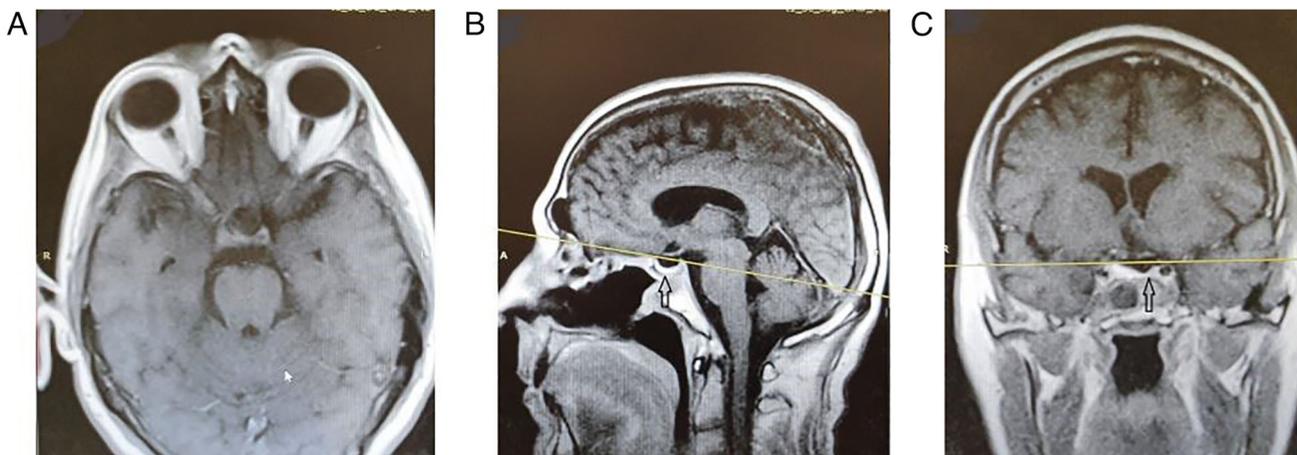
Post-operative (EET approach) contrast enhanced T1 magnetic resonance image following the endoscopic endonasal approach. (A) No residual tumor is depicted. (B and C) Note the meningoplasty grafts in the skull base (arrows). (C) The optic chiasma is free of compression.
